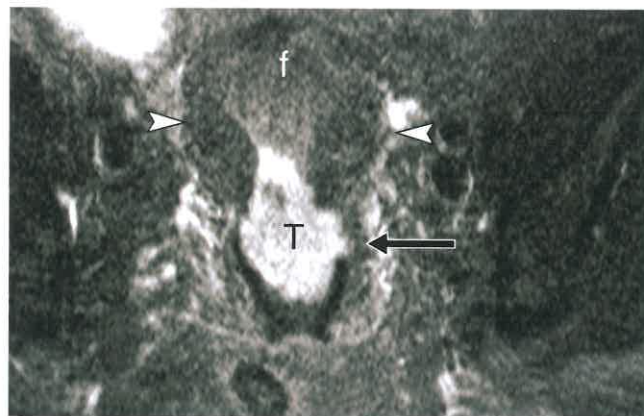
Endometrial Carcinoma—MR. Axial plane T2-weighted MR image through the uterus (between arrowheads) using fat saturation shows endometrial carcinoma (T) invading more than 50% of the thickness of the myometrium (arrow). This tumor is distinctly high signal compared to myometrium on this T2WI. f, fundus of the uterus.
